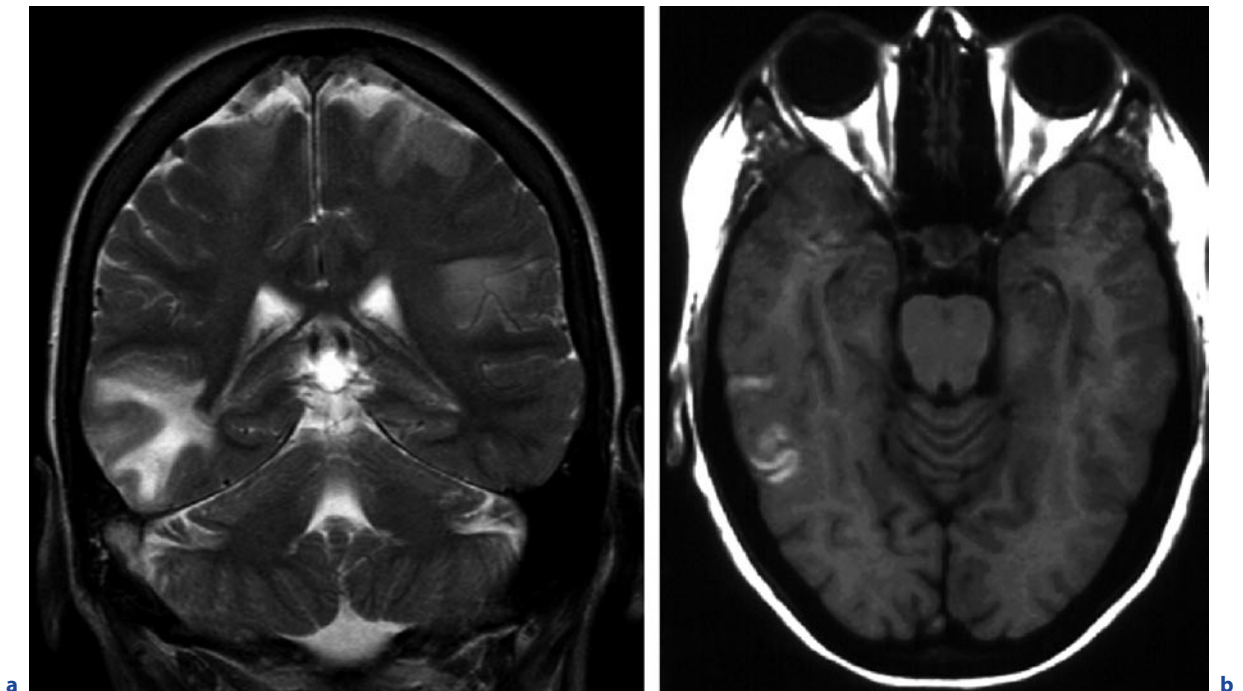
Vasogenic edema due to sinus thrombosis as differential diagnosis of cerebritis. A 36-year-old woman, headache, seizures for 10 days. a Axial T2-weighted image.
